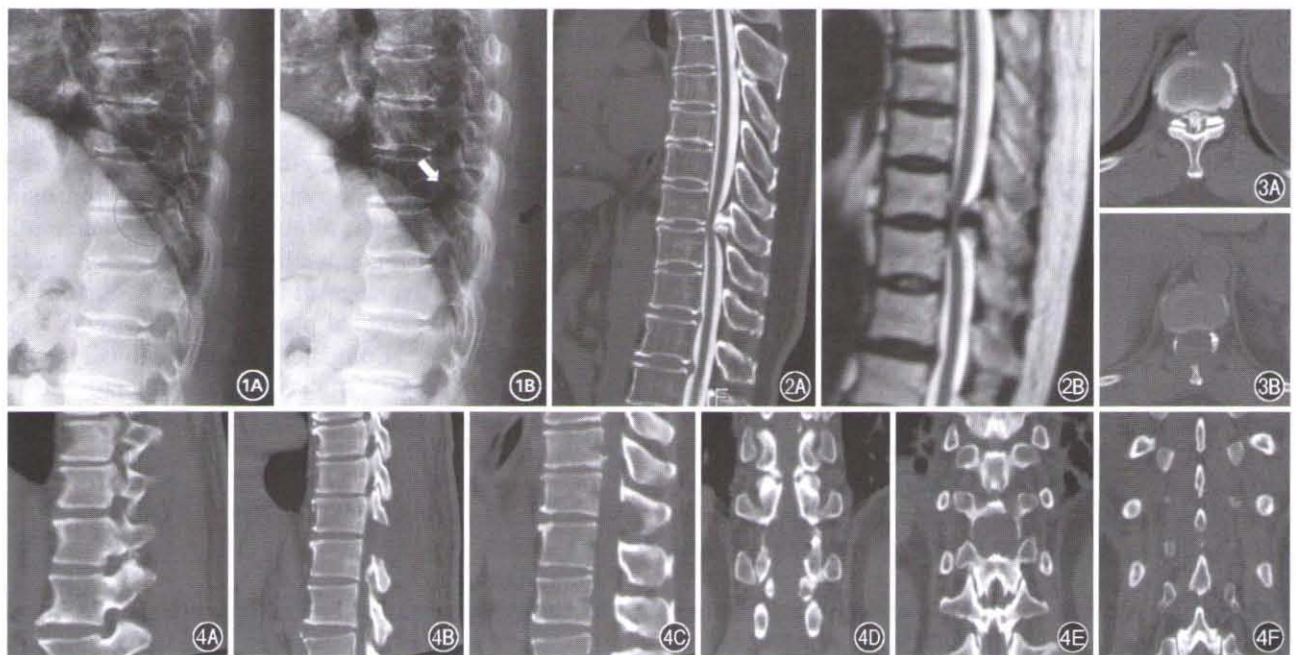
Preoperative and postoperative lateral X-ray films. The red circle indicates the segment to be operated on. 1A: ossification of the ligament flavum (OLF) is visible. 1B: the OLF has been resected (white arrow) and the spinous process has been preserved (black arrow).
